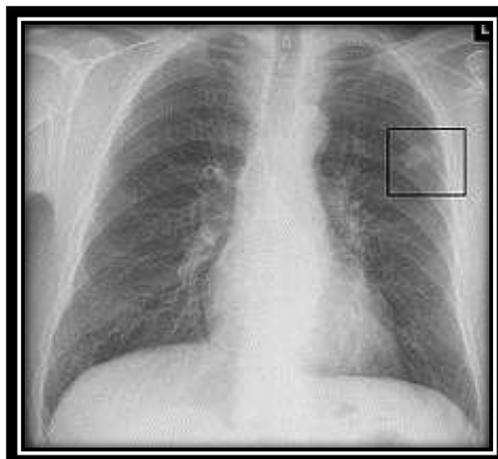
Chest x-ray showing lung cancer in the left lung.
